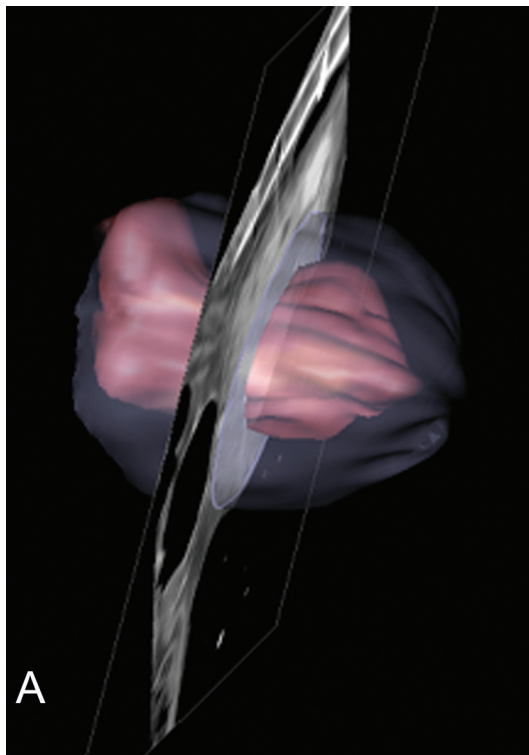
A, Three-dimensional (3D) left ventricular (LV) volume segmentation produced by the volume-rendering technique from a computed tomography data set. B, Automated volume segmentation by using a 3D region-growing algorithm. This software necessitates only the definition of the mitral valve level (red dashed line). The LV end-diastolic and end-systolic volumes are segmented automatically from the CT densities (in Hounsfield units; rose color). Upper left, short-axis view; upper right, 2-chamber view; bottom left, 4-chamber view.
